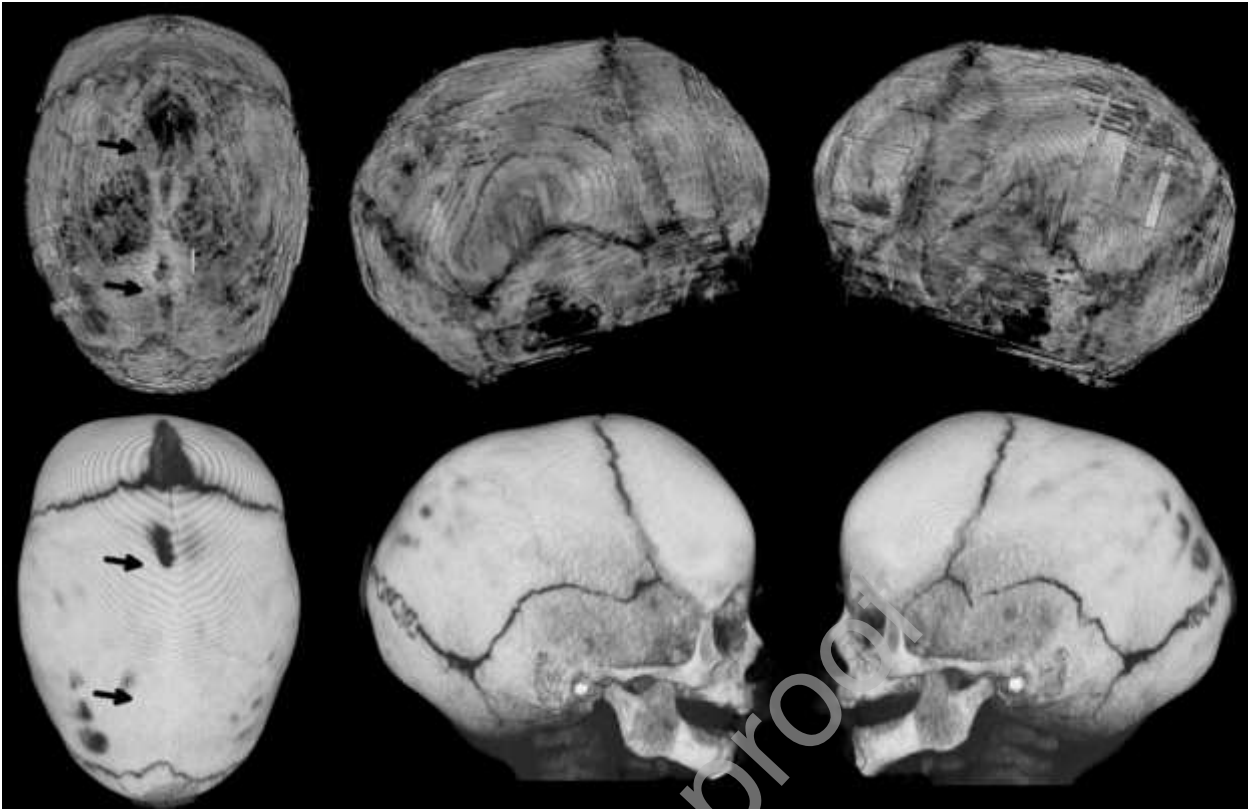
Skull images of patient 3 with sagittal synostosis. Top row, 3D-rendered BB-MRIs at the age of 2.6 months. Bottom row, 3D-rendered CT images at the age of 2.8 months. Imaging was performed in natural sleep after feeding. The arrows point to the location of the fused suture.
